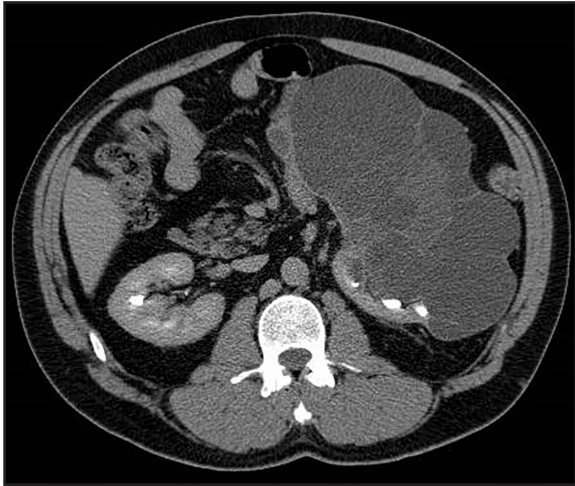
Tubulocystic renal cell carcinoma in a 67-year-old man. Axial CT contrast-enhanced image during excretory phase depicts a large, multiloculated cystic mass with minimally enhancing septations and solid components. This tumor was proven as tubulocystic RCC on surgical excision.
